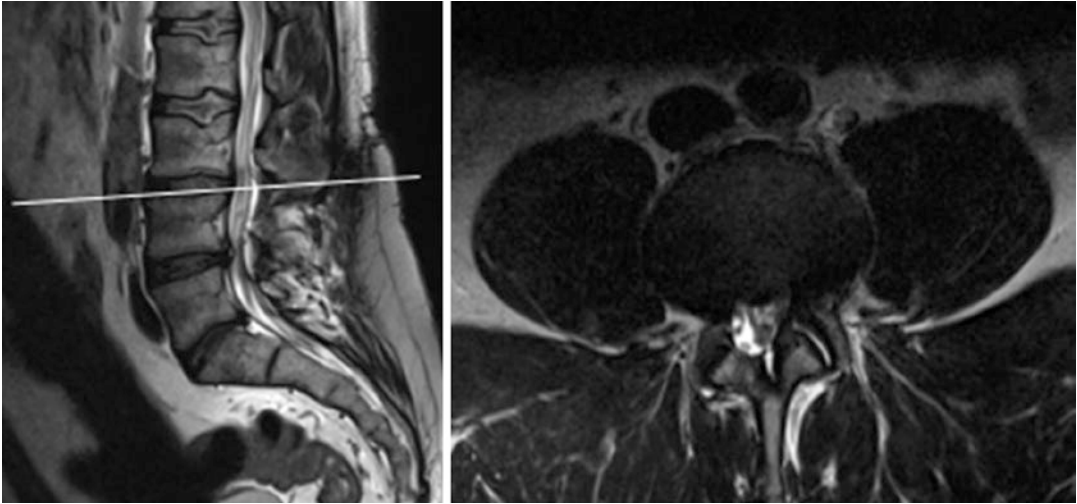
Sagittal (left) and axial (right) 1 year post-operative MRI showing absence of recurrent disc herniation and a complete nerve roots' decompression
